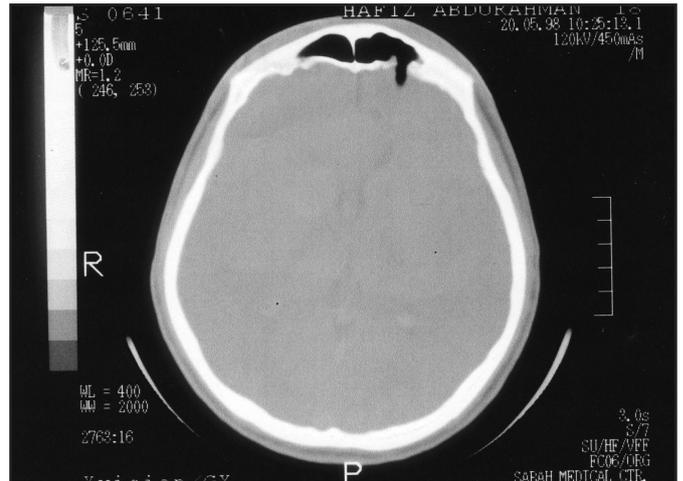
CT scan revealing fracture of posterior table of frontal sinus.
